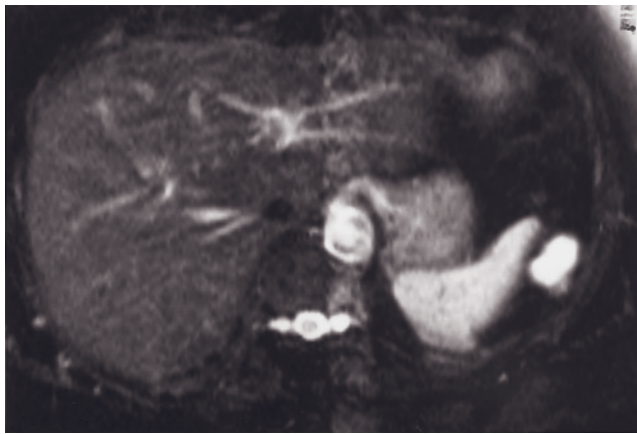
Hemangioma with perilesional enhancement. T2-weighted SS-ETSE (*a*) and immediate (*b*) and 90-s fat-suppressed (*c*) postgadolinium SGE images. This patient, who has an inflammatory pseudotumor arising in the common hepatic duct that causes dilatation of the biliary tree, also demonstrates a round, well-defined lesion, which is hyperintense on T2-weighted image (*a*) and shows peripheral nodular enhancement on the immediate postcontrast image (*b*) with nearly complete fill-in of the lesion on the delayed image (*c*). Note the transient ill-defined increased perilesional enhancement (arrow, *b*) on the immediate postcontrast image (*b*). Perilesional enhancement.
